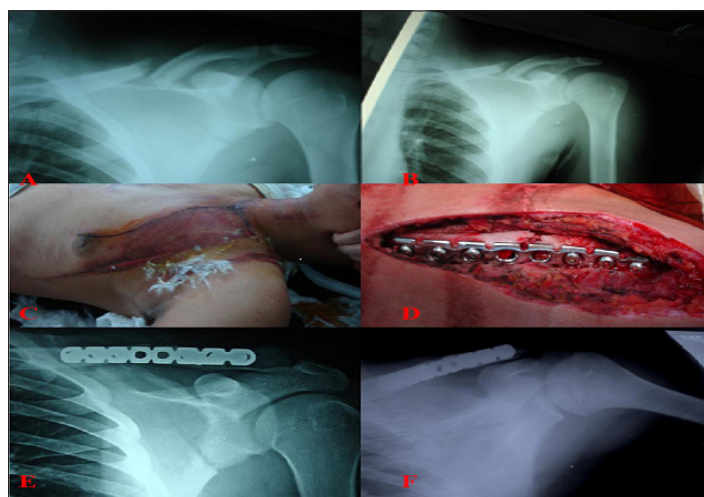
Male Patient 38 Years Old with Floating Shoulder Injury: A&B) Preoperative X-Ray; C) Photo Shows the Clinical Appearance of the Patient Preoperative; D) Intraoperative Photo Shows Fracture Clavicle After Open Reduction and Internal Fixation; E) X-Ray 1month Postoperative; F) X-Ray 15 Months Postoperative with Both Fractures United.
